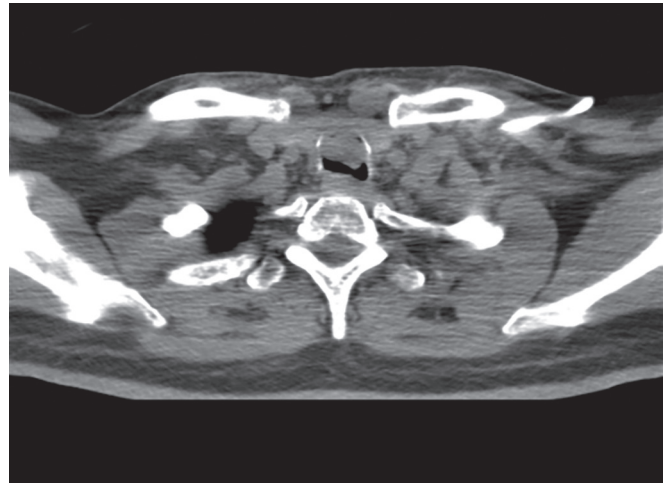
The CT scan showing the low location of the tumor in the trachea at the level of the suprasternal notch
